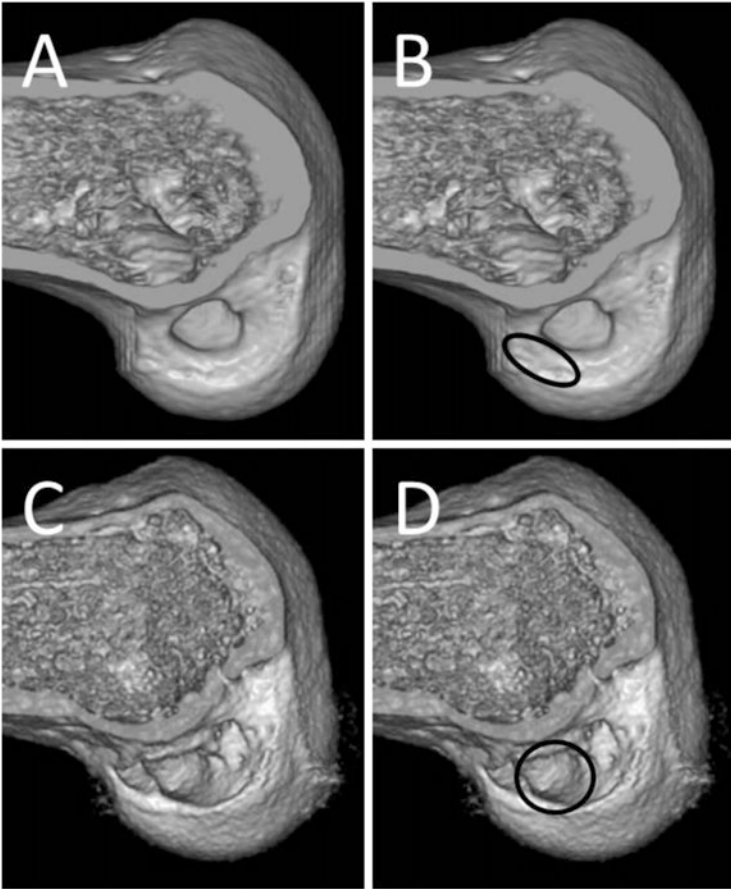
(a, b) Preoperative three-dimensional (3D) computed tomography (CT) images of the *left knee* showing a previous incompletely malpositioned femoral tunnel. (b) The *black ellipse* shows a new anatomical rectangular tunnel location in a revision procedure with a bone-patellar tendon-bone (BPTB) graft without communication with the previous tunnel. (c, d) Preoperative 3D CT images of the *left knee* showing an anatomical positioned femoral tunnel with large tunnel widening. (d) The *black circle* shows a tunnel position in a revision procedure using a BPTB graft with the largest possible trapezoidal bone block as a substitute for rectangular BPTB reconstruction
